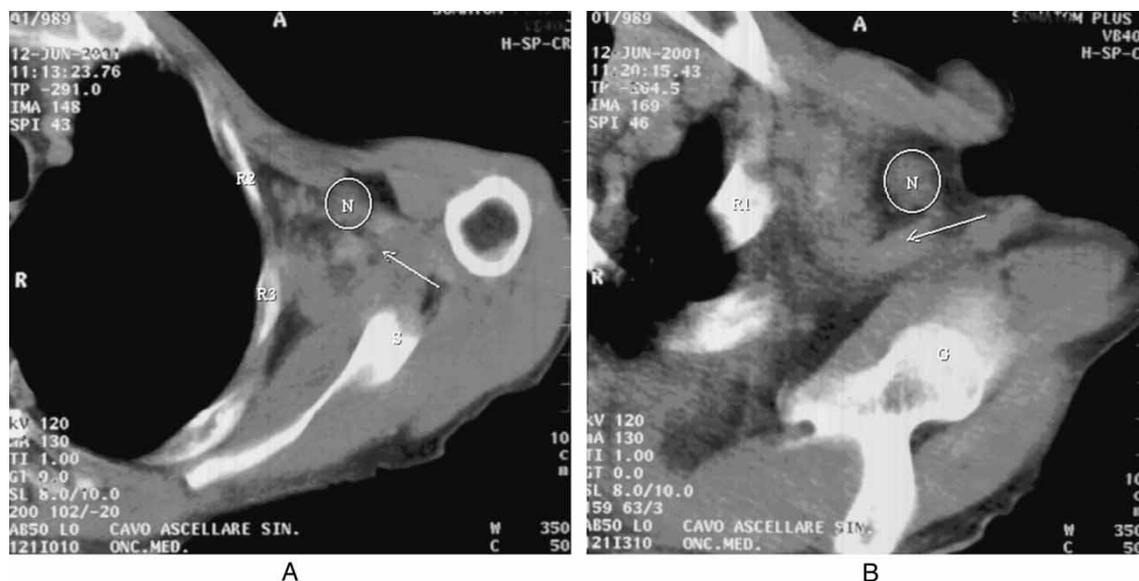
A 35-year-old man with Hodgkin's disease. A: A 4-mm-thick CT scan through the left axilla in akimbo position shows enlarged lower axillary node (N) at the level of the second intercostal space and scapular body (S). Axillary vessels (arrow) can be seen behind the enlarged node. R2: Second rib; R3: Third rib. B: A 4-mm-thick CT scan obtained with arms held up over the head demonstrates that the enlarged node (N) is displaced at the level of the first rib (R1) and inferior glenoid rim (G).
